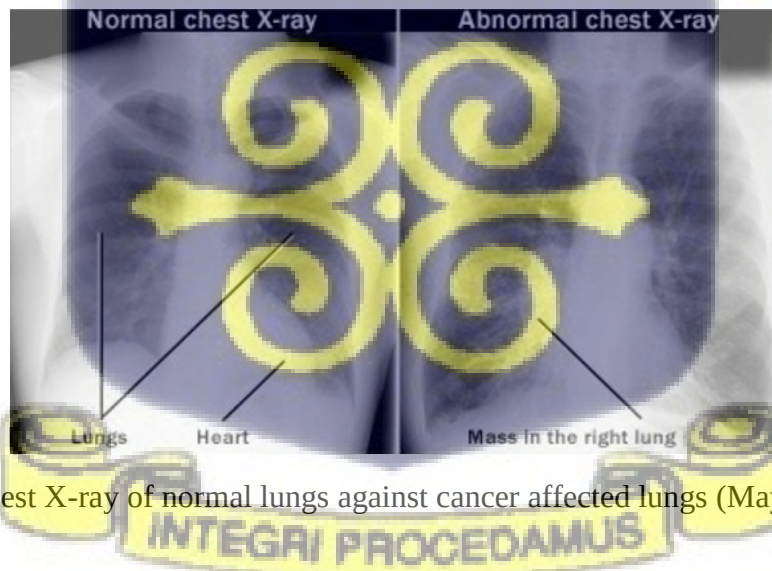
Chest X-ray of normal lungs against cancer affected lungs (Mayo Clinic, 2020)
